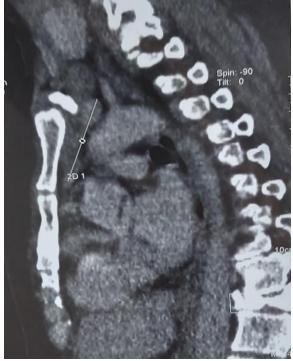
CT scan shows a quadrilatral antero superior mediastinal structure, measuring 53x23x55mm
